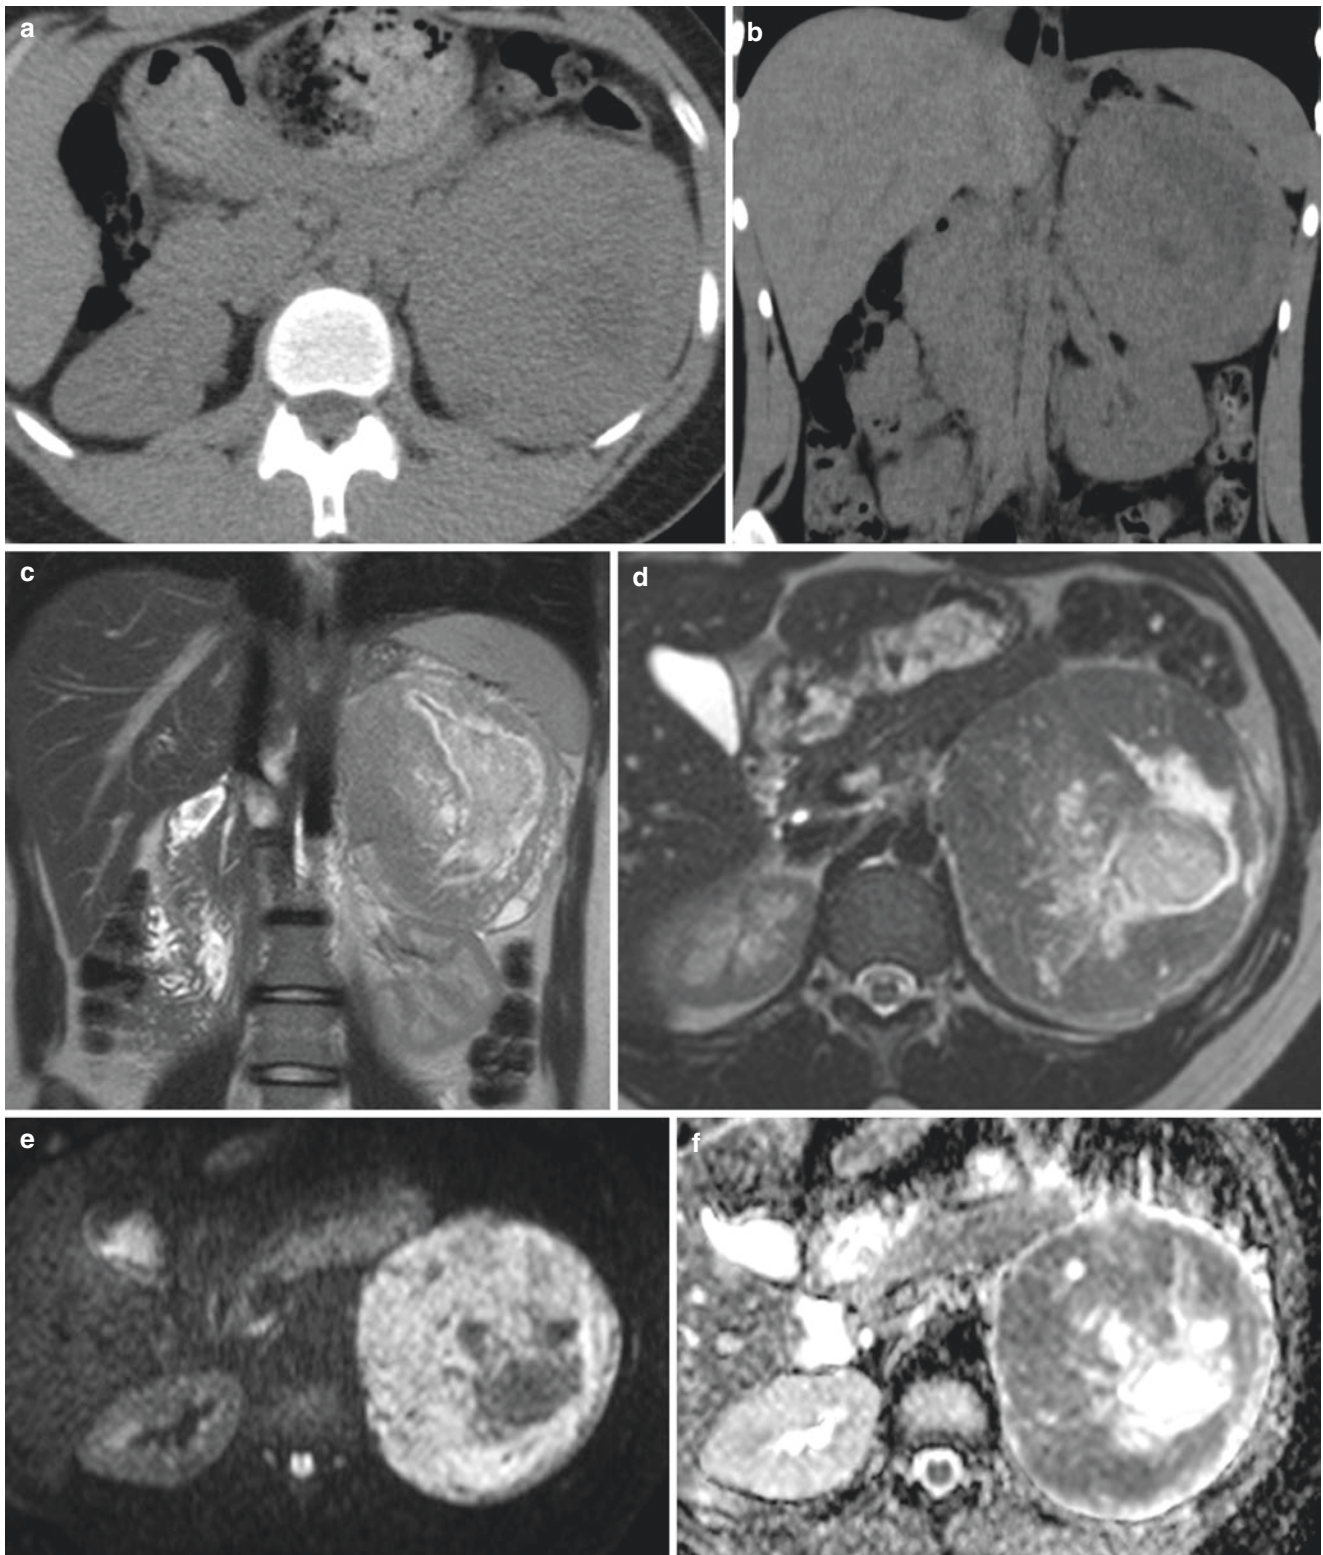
Adrenocortical carcinoma. Axial (a) and coronal reconstruction (a) of CT without IV contrast and coronal (c) and axial (a) T2-weighted MR images with diffusion-weighted image (e), ADC map (f), and pre-(g) and post-gadolinium (h–j) T1-weighted MR images.
